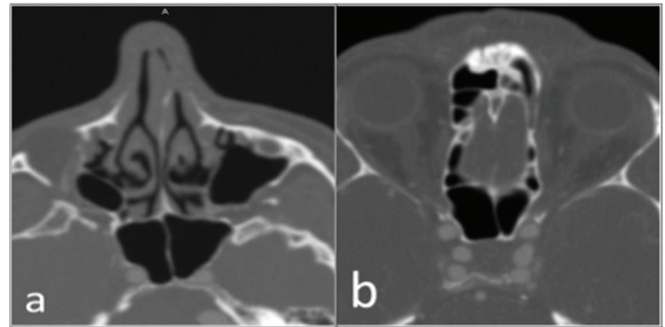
Deviation patterns of the main sphenoid septum. Axial computed tomography angiography (CTA) image (a) shows no deviation of the main sphenoid septum. In another axial CTA image (b), although there is no lateralization at the main sphenoid septum according to its anterior and posterior end points (not shown), left deviation is seen at pituitary gland level.
